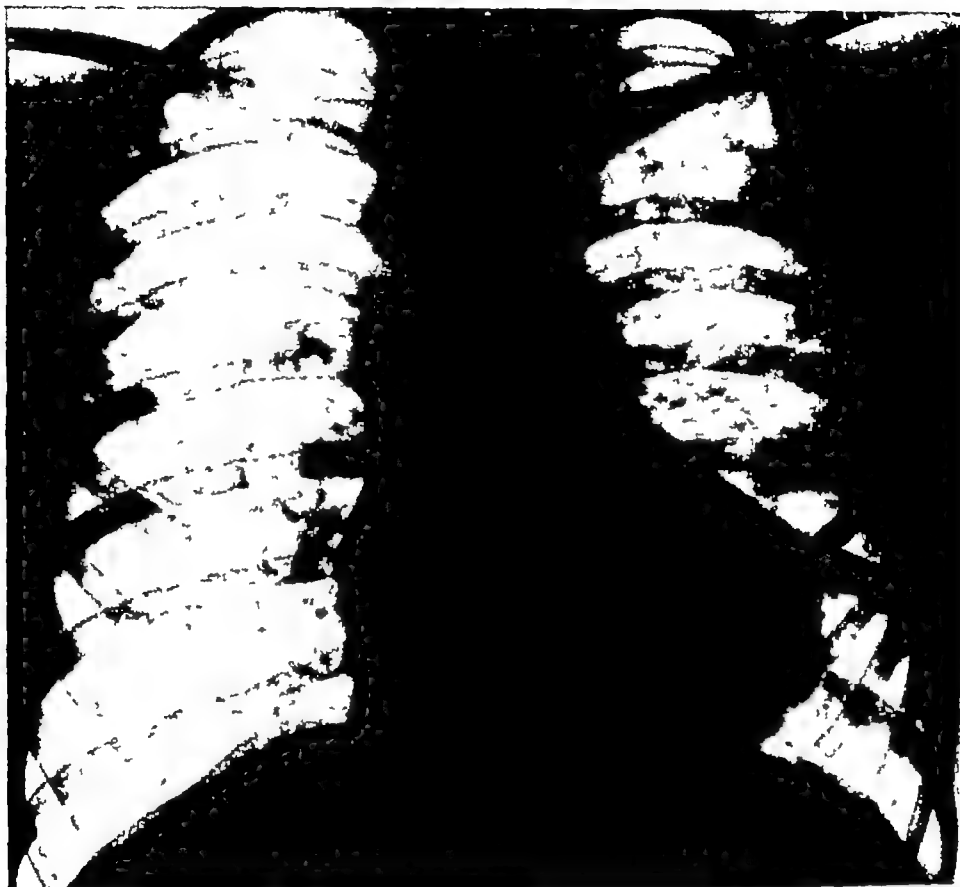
Radiograph of a patient showing the boot-shaped heart characteristic of Fallot's tetralogy
